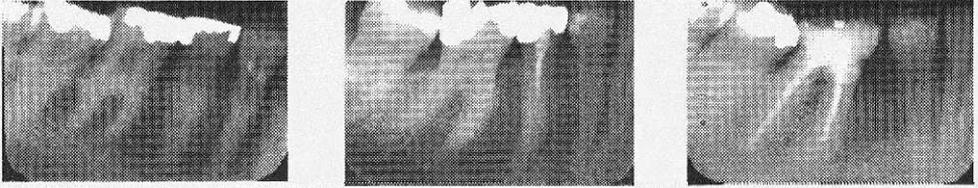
The three reference radiographs used to assess the trabecular pattern with the visual index: sparse trabeculation, alternating dense and sparse trabeculation, and dense trabeculation.
